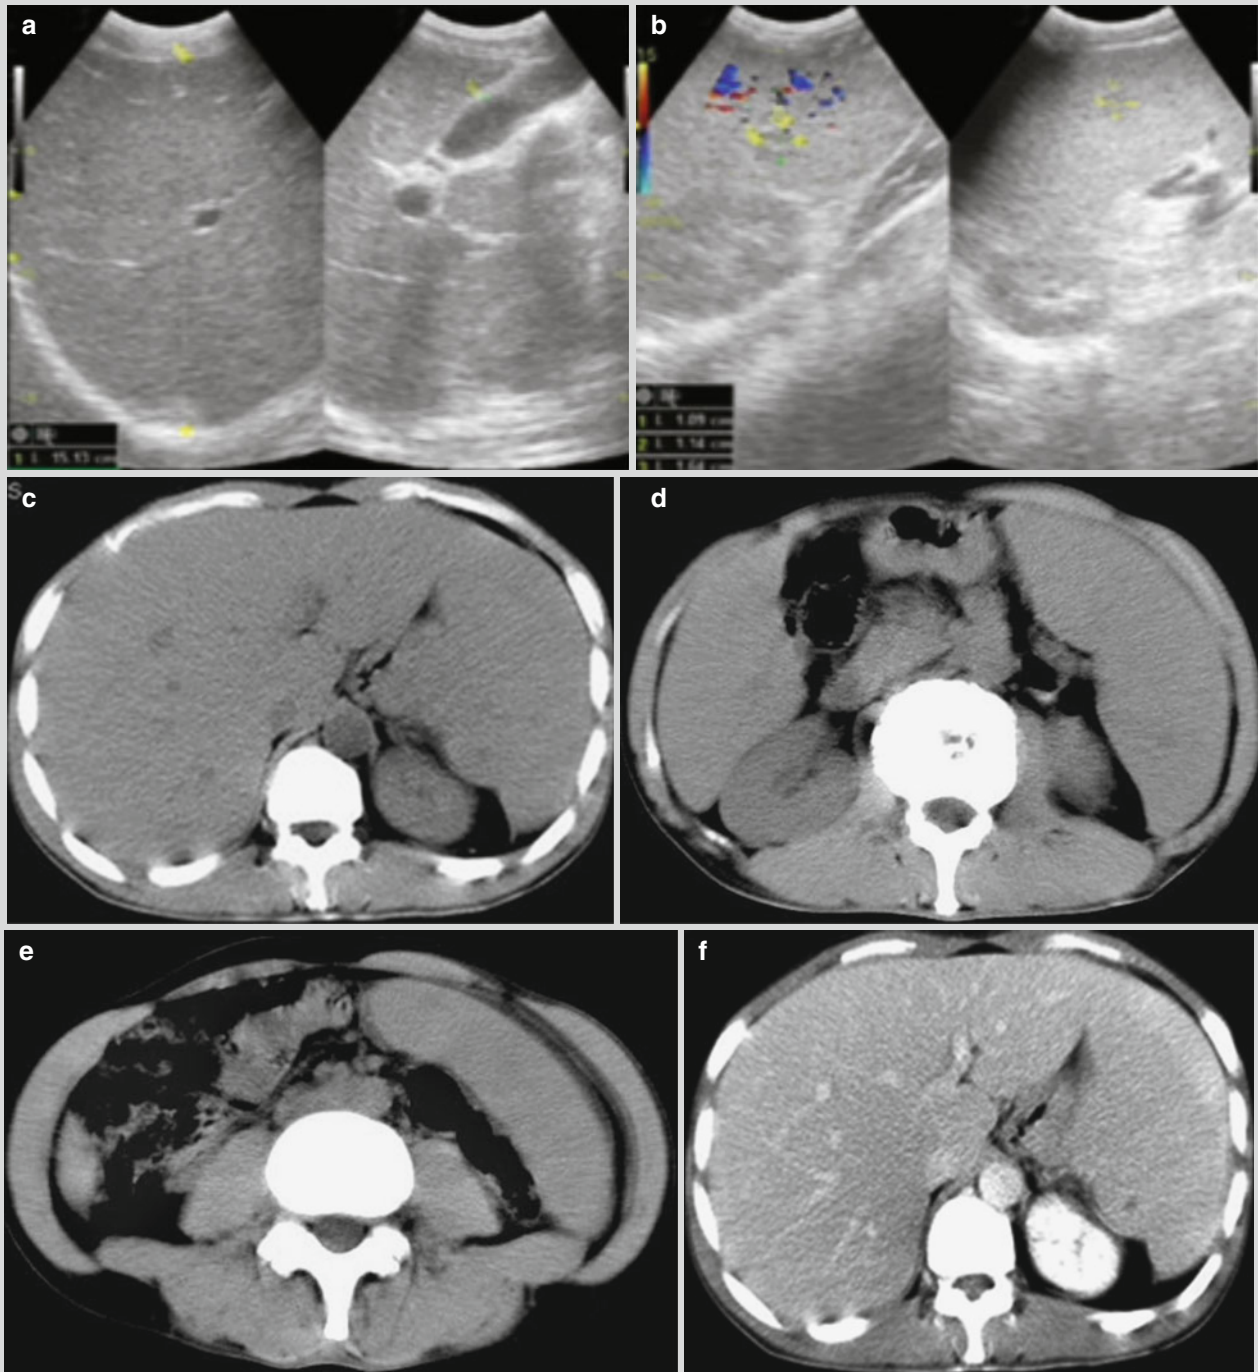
Hepatic and splenic lesions of visceral leishmaniasis. (a, b) Ultrasonography reveals enlarged liver, with a maximum oblique diameter of 151 mm of the right hepatic lobe. The liver is morphologically well stacked, with two solid foci in different sizes in the upper segment of the right hepatic lobe. The foci have clearly defined borders and even inner echo, with no obvious blood flow signal around or in them. Ultrasonography also reveals enlarged
